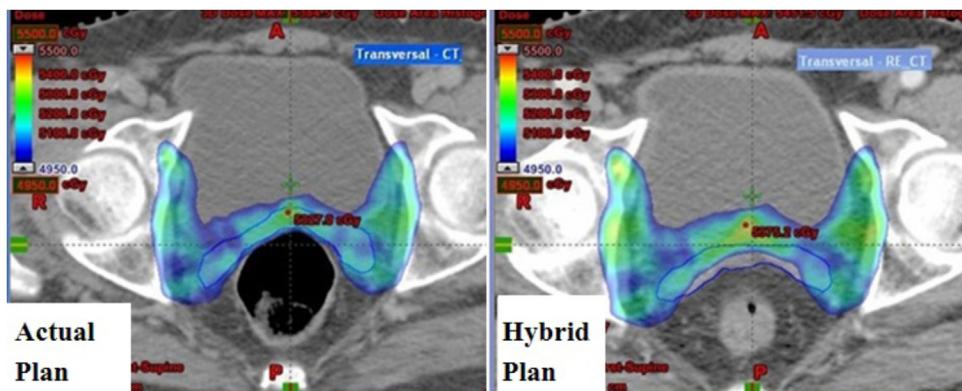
Dose distribution on one of the CT image of actual plan done on first day planning CT images having rectum filled with gas, and of the hybrid plan on re-CT images without significant gas in the rectum.
